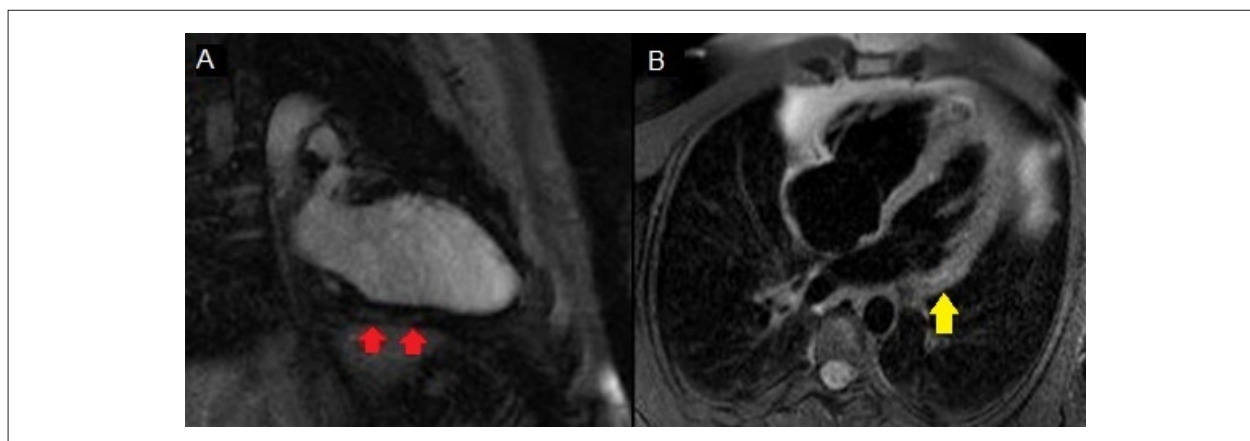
Cardiovascular magnetic resonance imaging. (A) T1-weighted image demonstrating patchy subepicardial late gadolinium enhancement (red arrows) in the basal portion of the inferior wall; (B) T2-weighted image presenting focal regions of increased signal intensity (yellow arrow) suggestive of slight oedema in the inferolateral wall.
